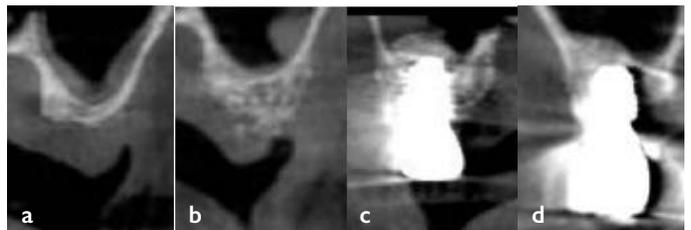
CT scans taken before bone grafting, after bone grafting, after implant placement, and after completing the finalrestoration of tooth #17, respectively
